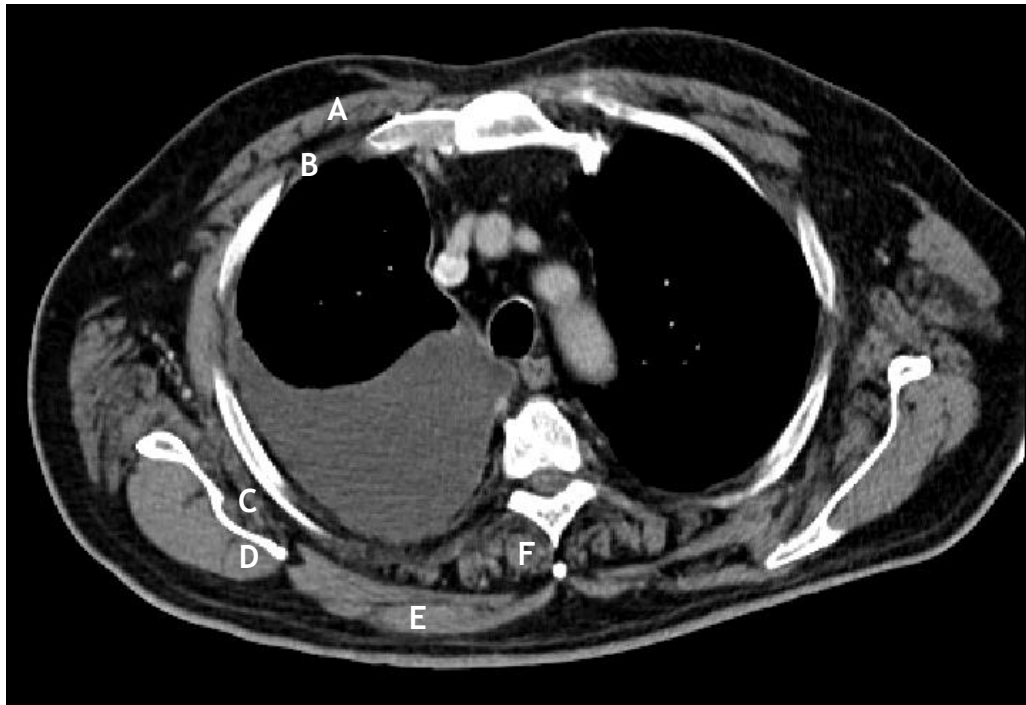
Single axial contrast-enhanced CT image of a patient with MPM demonstrating the muscles at the fourth thoracic vertebra (T4) which includes the pectoralis (A), intercostals (B), sub-scapularis (C), infraspinatus (D), trapezius(E) and erector spinae (F)
